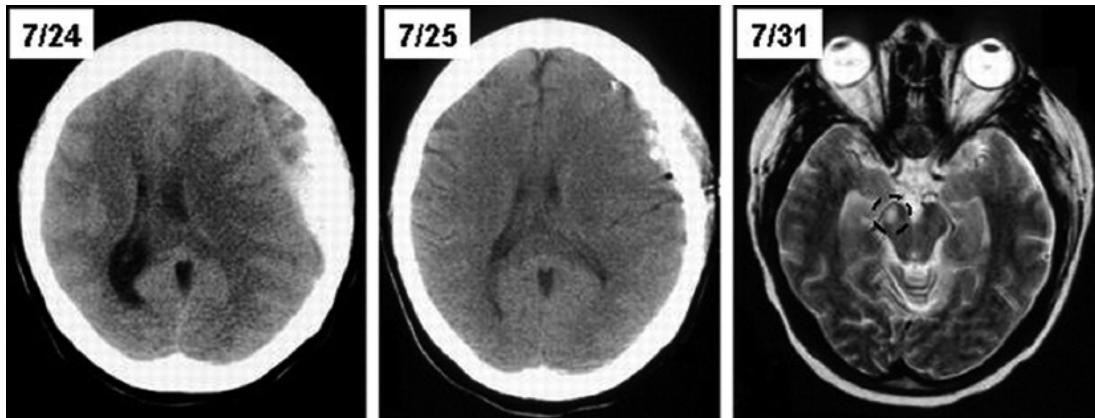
CT brain scan showed a left subdural hematoma with 1.5 cm midline shift (panel 7/24). After emergency platelet transfusion, the subdural hematoma was evacuated. Brain CT the next day showed resolution of the shift (panel 7/25). Brain MRI a week later showed a cerebral peduncle lesion in the T2-weighted sequence (panel 7/31). There was no history of head trauma.
